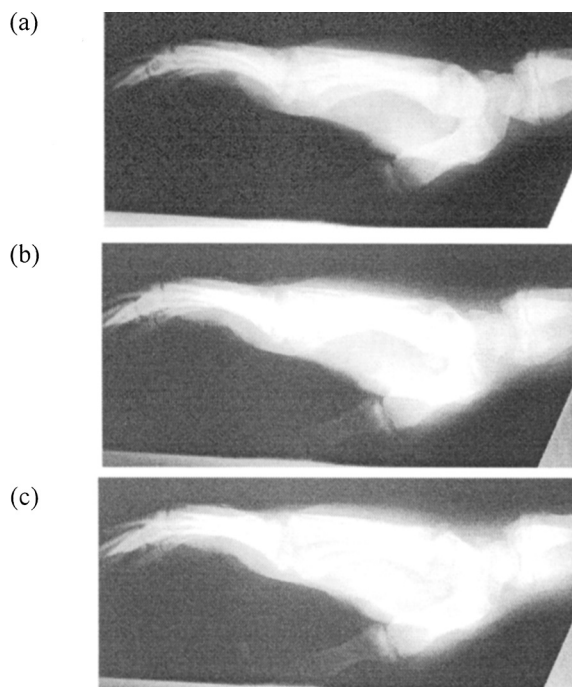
Radiograph of a hand with (a) no masking, (b) edge masked only and (c) fully masked.
